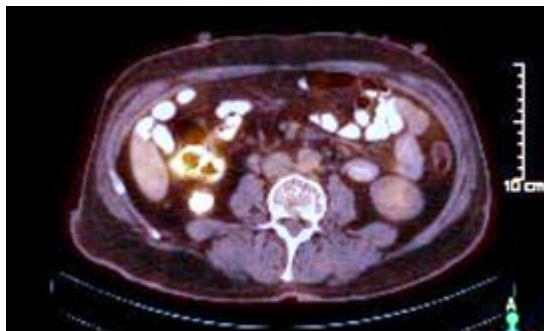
A 26x41x31mm size bilobed, central hypodense, heterogeneous hypermetabolic (SUVmax: 7.5) soft tissue lesion was seen on PET CT
